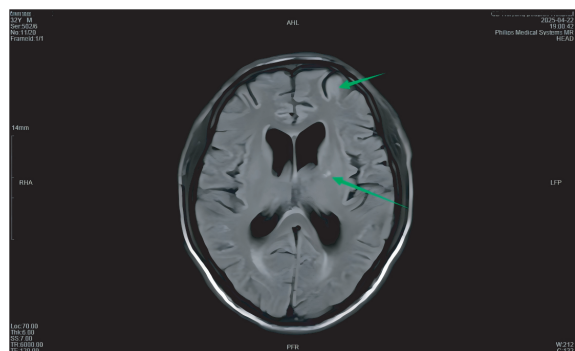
Brain MRI display left basal ganglia region, left frontal lobe infectious lesions)
